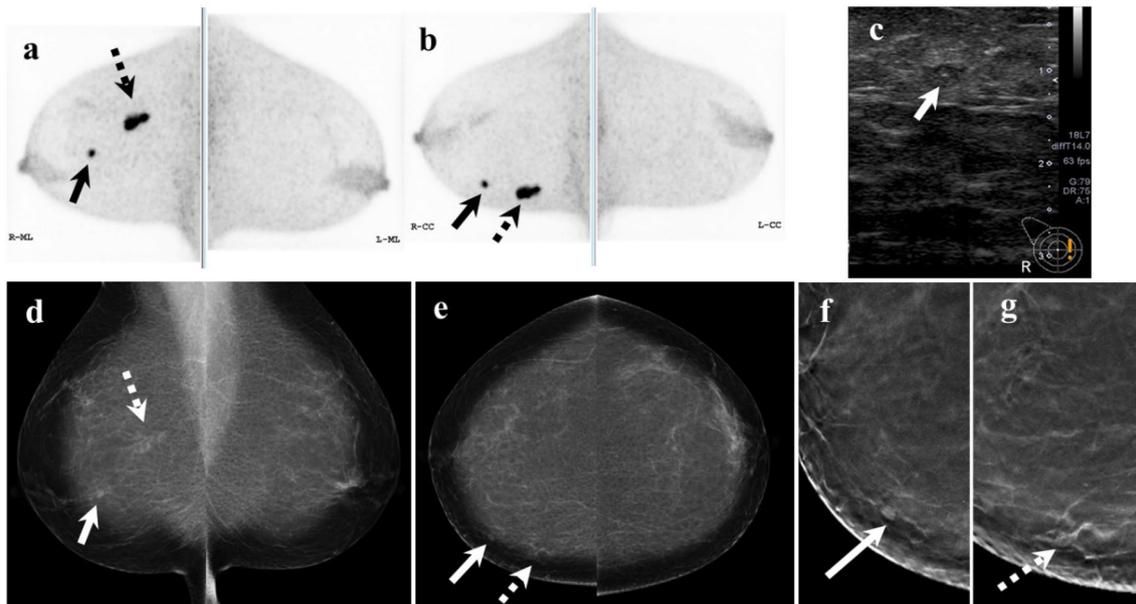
DbPET-positive invasive ductal carcinoma of the right breast (woman aged in 70 s). Pathological stage IA, luminal B subtype, nuclear grade 3, and Ki-67 27%. The mediolateral (ML) view (a) and the craniocaudal (CC) view (b) of dbPET with the PET window intensity of SUV 0 to 3, the sagittal view of breast ultrasound (US) (c), the mediolateral oblique (MLO) view (d) and the CC (e) view of digital mammography (DM), and enlarged CC views (f, g) of digital breast tomosynthesis (DBT). At the screening, DM-DBT
